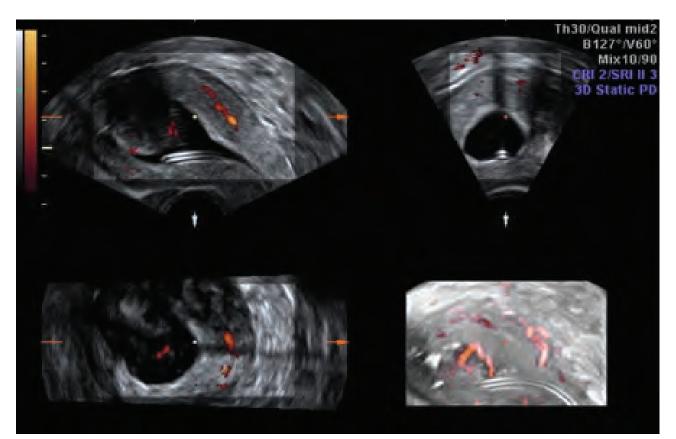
The three dimensional saline infusion sonography of submucosal fibroid
